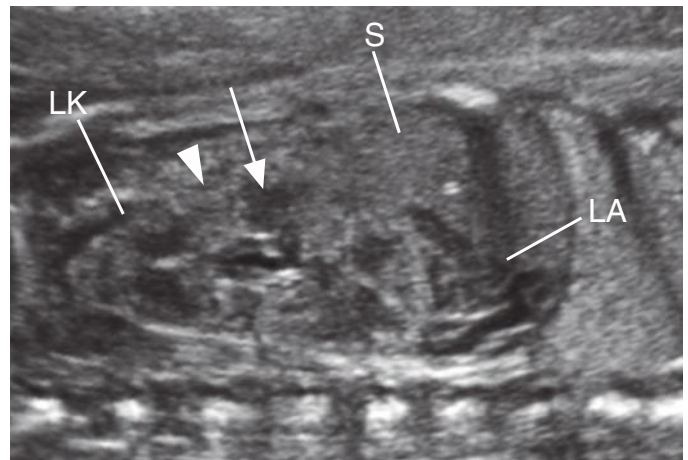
Sonogram of a fetal left kidney (LK) in longitudinal axis. The medullary pyramids (*arrow*) are darker, triangular areas distinguishable from the surrounding cortical tissues and septa of Bertin (*arrowhead*). LA, left adrenal gland; S, spleen.
